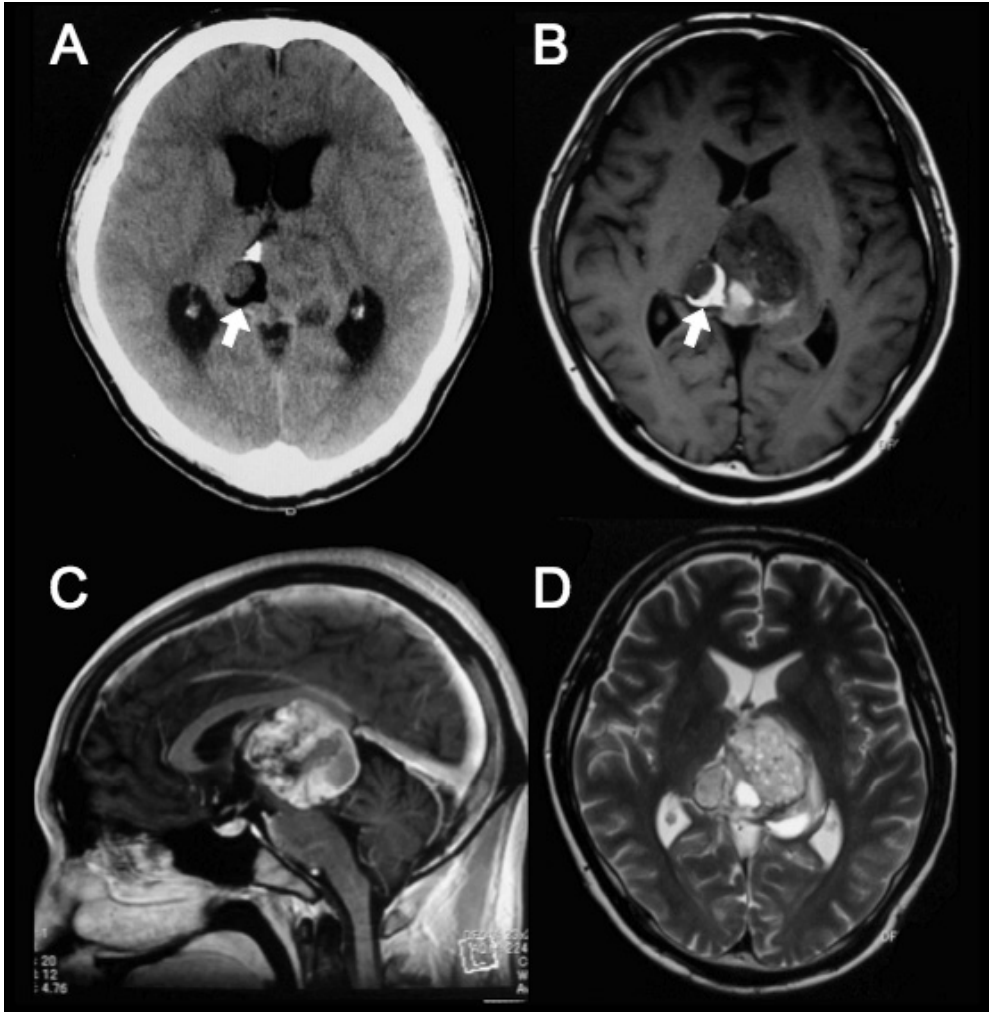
Mixed germ cell tumor composed of immature teratoma and yolk sac tumor. The tumor contains calcification and fatty tissue. The low-density area evident on CT (white arrow, A) or the area of high signal intensity (white arrow, B) on the T1-weighted image indicates the presence of fatty tissue. The tumor is heterogeneously enhanced (C). The T2-weighted image also shows a heterogeneous pattern (D).
